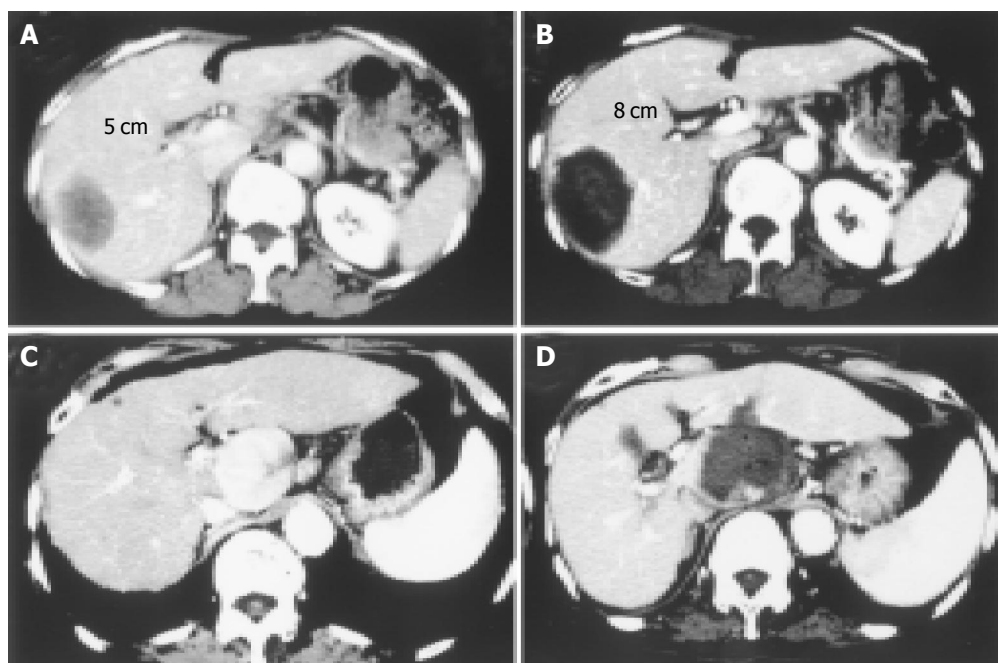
Two cases with large-sized HCC treated with PEI-RFA are shown. Contrast-enhanced CT before (A: delay phase, C: early vascular phase) and after (B: delay phase, D: delay phase) PEI-RFA. Massive HCCs of 5 cm in the longest diameter were located in the right lobe of the liver in both cases. In the first case (A and B), RFA was started at 30 W and the power output was increased stepwise to 100 W every two min and the ablation was performed for 20 min. In the second case (C and D), because the tumor was located close by blood vessel such as inferior vena cava, portal tract and aorta, it was likely to be difficult to treat with RFA under high power control. After injecting 19 mL of ethanol into the tumor, one session of RFA was performed at 30 W for 12 min. The massive tumor was completely eliminated by PEI-RFA.
